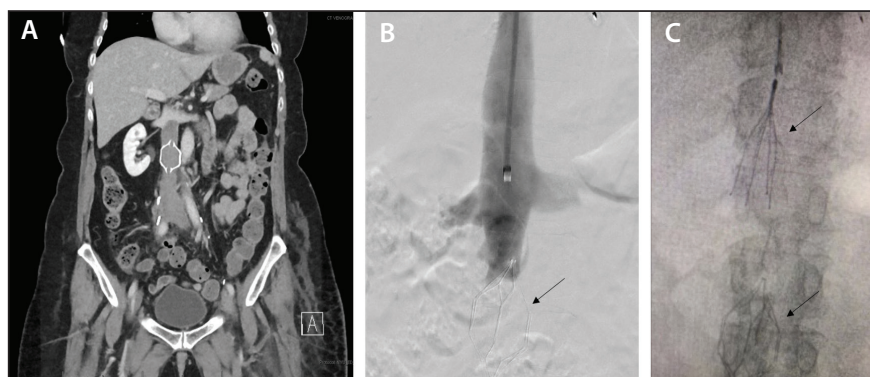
Initial CTA (A). Venogram obtained from the initial internal jugular access for deployment of the second filter (suprarenal); the initially present OptEase filter is marked via an arrow (B). Postdeployment of the second filter with black arrows marking both the OptEase initial filter and the newly deployed suprarenal filter (C).
